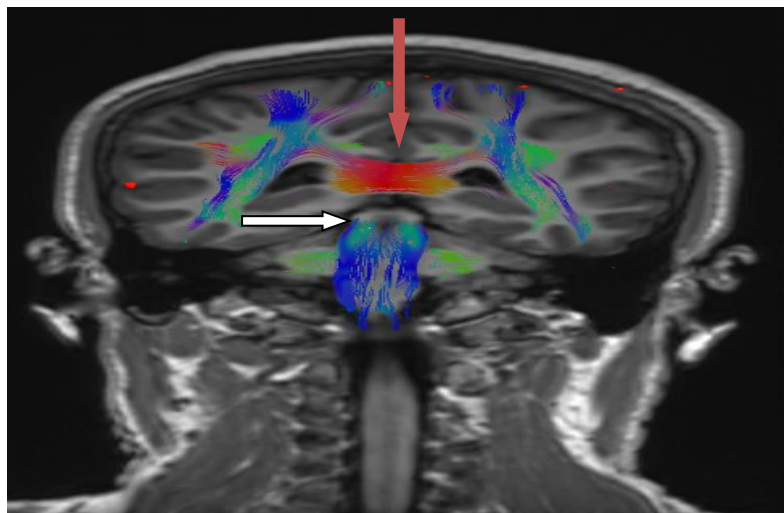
Coronal MRI DTI images of the same patient reveals normal fibers of corticospinal tract (White arrow) and corpus callosum (red arrow)
